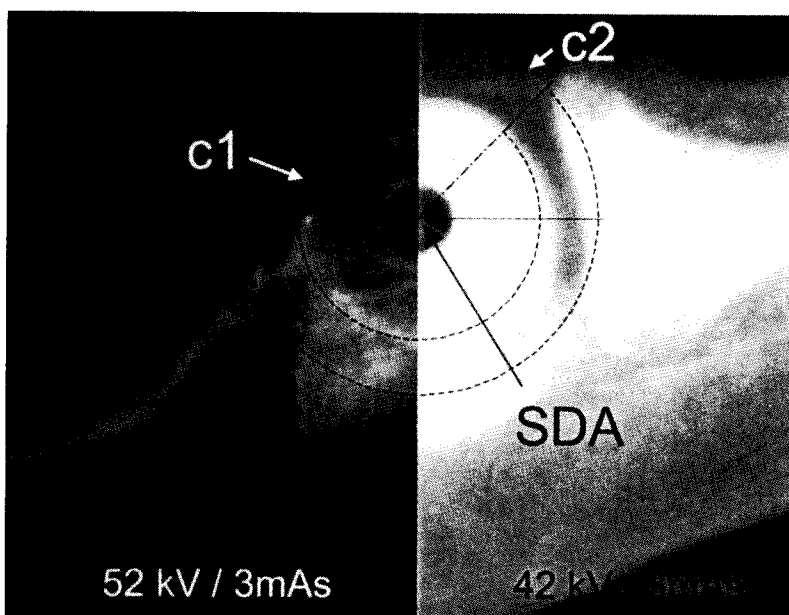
Lead marker study, relating anatomical landmarks to the radiographic indices RD (relative distance) and CD (center disparity). a: Relative distance is based on the projections of a flat cortical plate (p) of the posteromedial aspect of the distal humerus onto the radiodense line A. b: Center disparity is based on two apparently concentric circular radiographic shadows formed by the superimposed capitellum (c1) and trochlear sulcus (c3) and the medial flange of the trochlea (c2).
